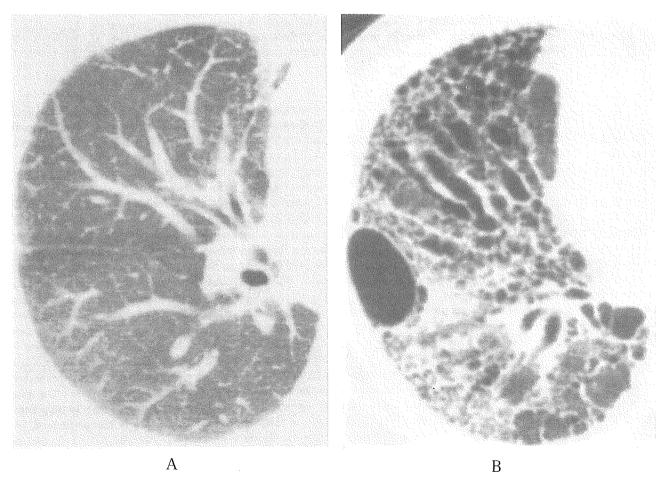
Chest computed tomography (A, Right lower lobe, April 1997; B, Right lower lobe, May 2004). During the follow-up period, ground glass opacity accompanied by traction-bronchiectasis developed along the broncho-vascular bundles, and subpleural bullae were also found.
